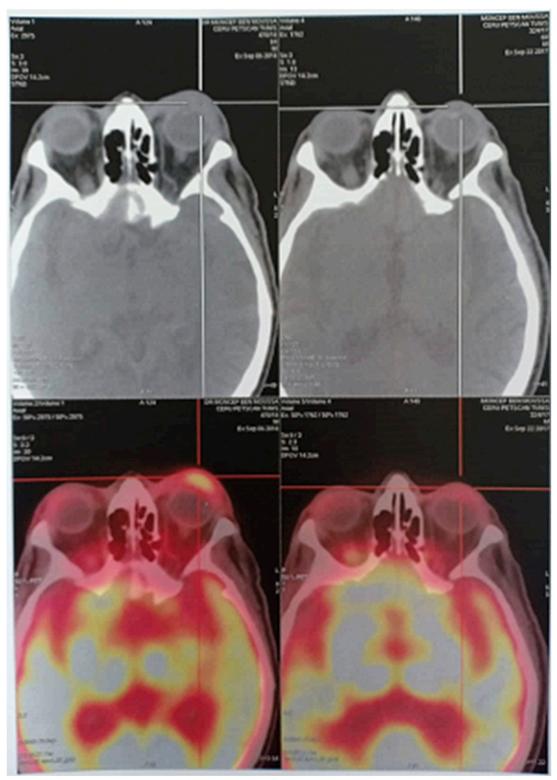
Positron emission tomography-computed tomography with the full-color images showing pathologic fluorodeoxyglucose uptake in the eyelid.
